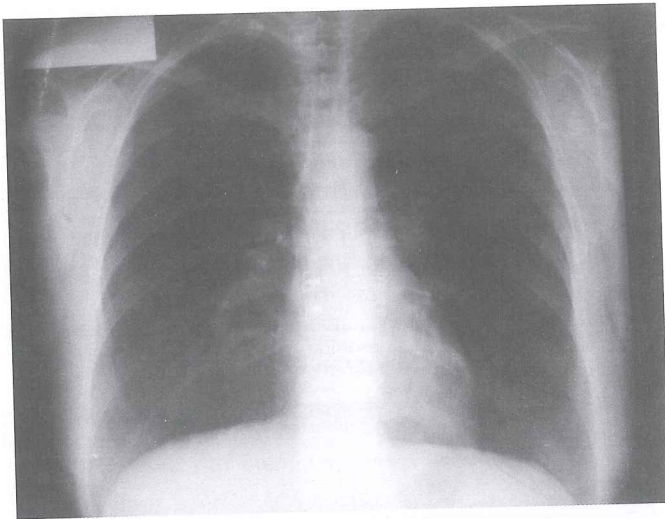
The chest X-ray of the patient on the day before the second bronchoscopy.
